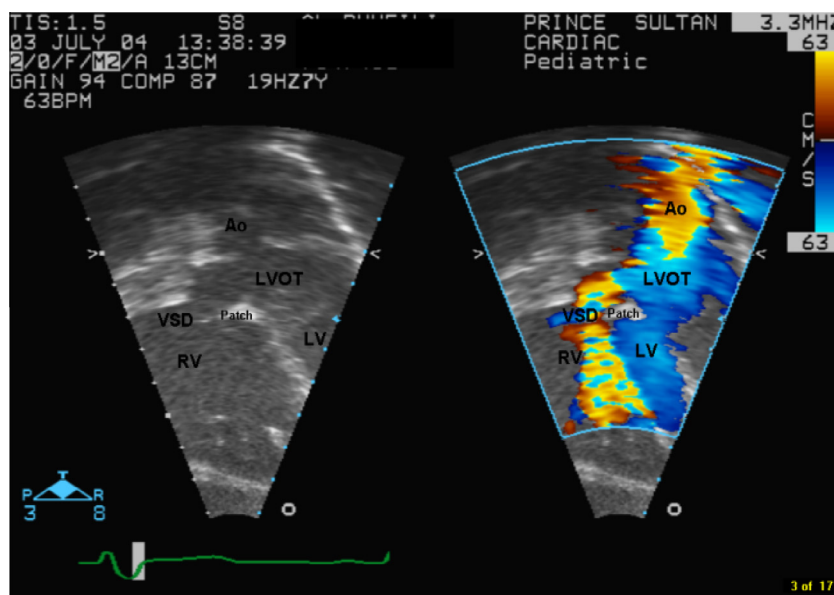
Pre-ventricular septal defect device deployment. Colour Doppler used to compare flow demonstrates residual interventricular communication between the upper margin of the ventricular septal defect patch and the free right ventricle wall. Ao, aorta; LV, left ventricle; LVOT, left ventricular outflow tract; RV, right ventricle; VSD, ventricular septal defect.
